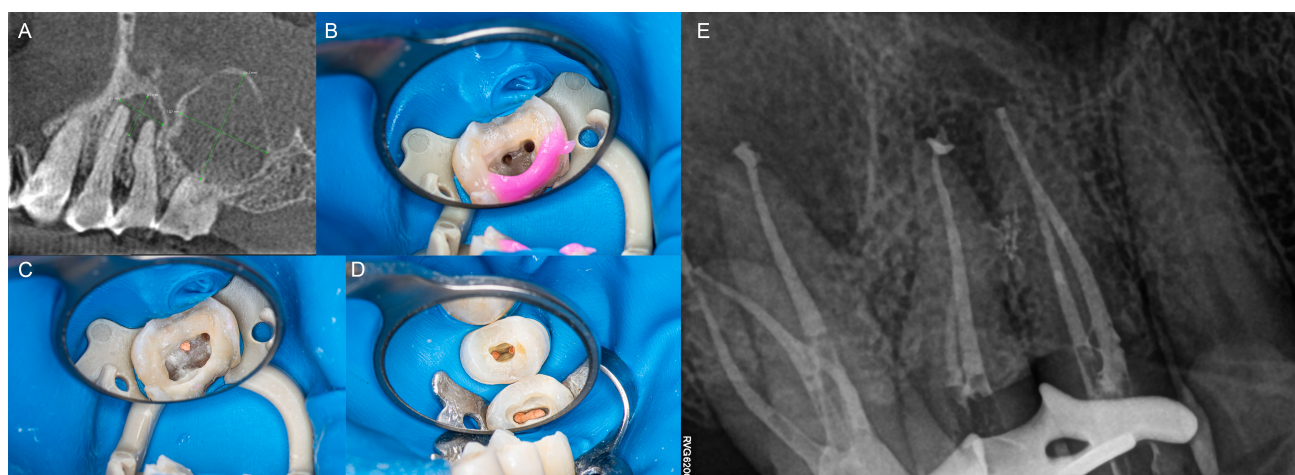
Endodontic treatment of the teeth. (A) Pre-operative cone-beam computed tomography (CBCT) showing both lesions with measurements. (7.1 mm by 6.1 mm and 13.7 mm by 16.3 mm). (B) First upper molar during endodontic treatment: stage after root canal preparation and irrigation. (C) First upper molar during endodontic treatment: stage after root canal obturation. (D) First and second upper premolars during endodontic treatment: stage after root canal obturation. (E) The post-endodontic treatment.
